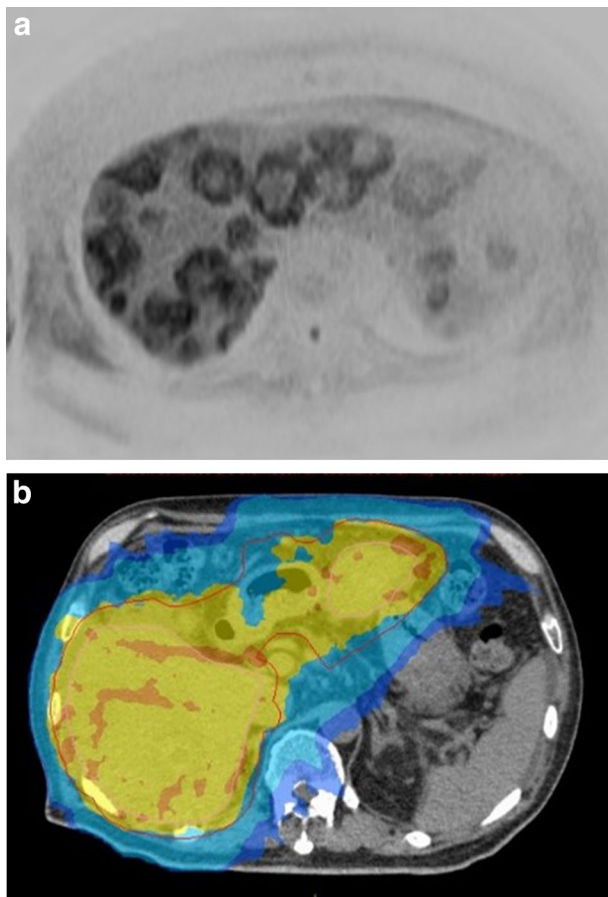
a Abdominal diffusion-weighted magnetic resonance imaging showed the progression of multiple liver metastases. b Abdominal computed tomography of the target zone of palliative low-dose whole-liver radiation therapy. Gross target volume is the whole liver. The yellow color zone indicates 100% of prescribed dose (30 Gy). The light blue color zone indicates 95% of prescribed dose. The blue color zone indicates 50% of prescribed dose
